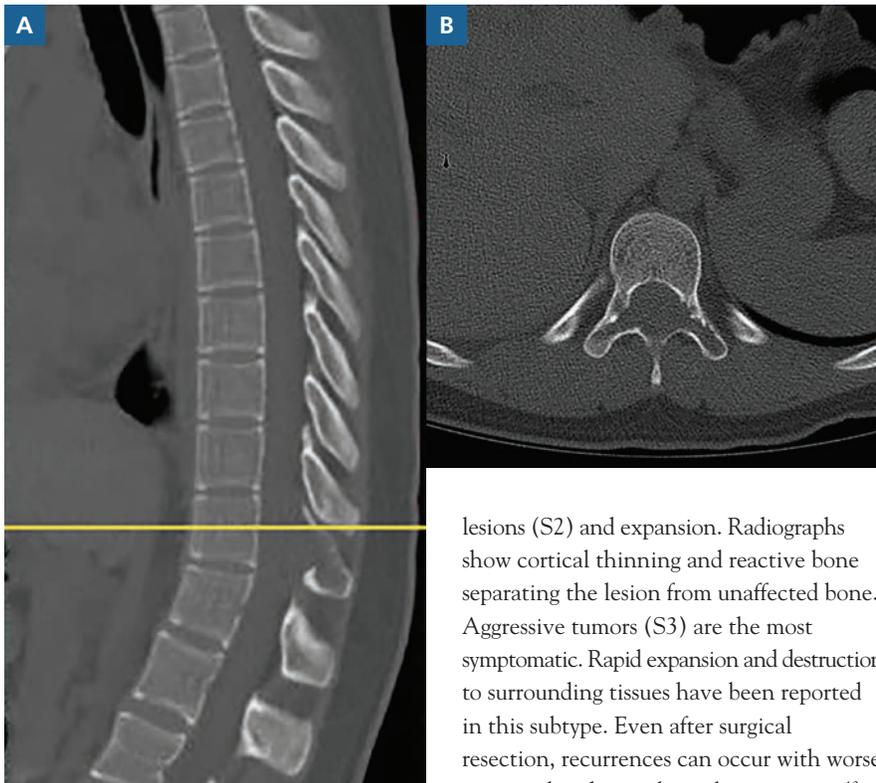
Preoperative A, sagittal and B, axial CT views. A lytic mass involving the posterior elements of the T11 vertebrae is visible, with erosion of the normal trabeculae resulting in communication with the spinal canal.
